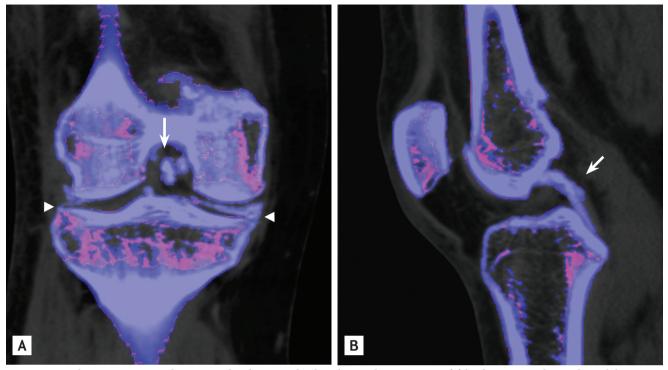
Dual energy computed tomography shows multiple calcium depositions in (A) both menisci, femoral condylar cartilage (arrowheads) and posterior cruciate ligament (arrow) and (B) anterior cruciate ligament (arrow).
